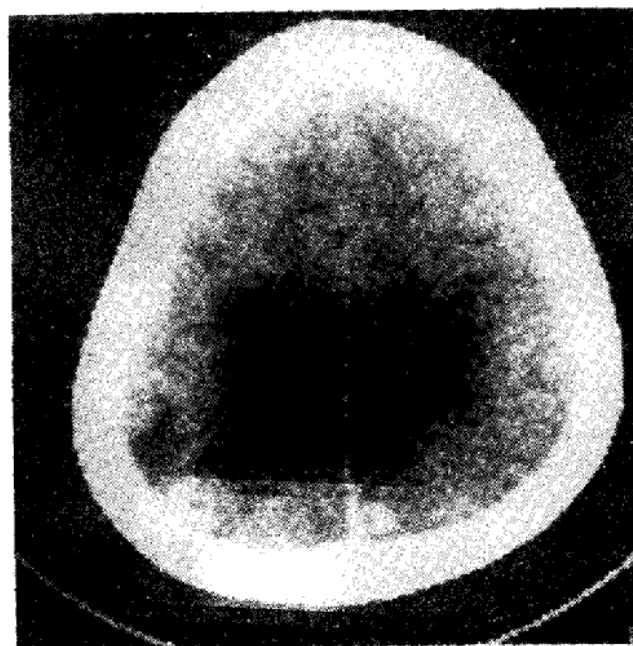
Cysticercosis with epilepsy (a) CT showing multiple enhancing lesions on either hemisphere, note edema surrounding right parietal lesions.
